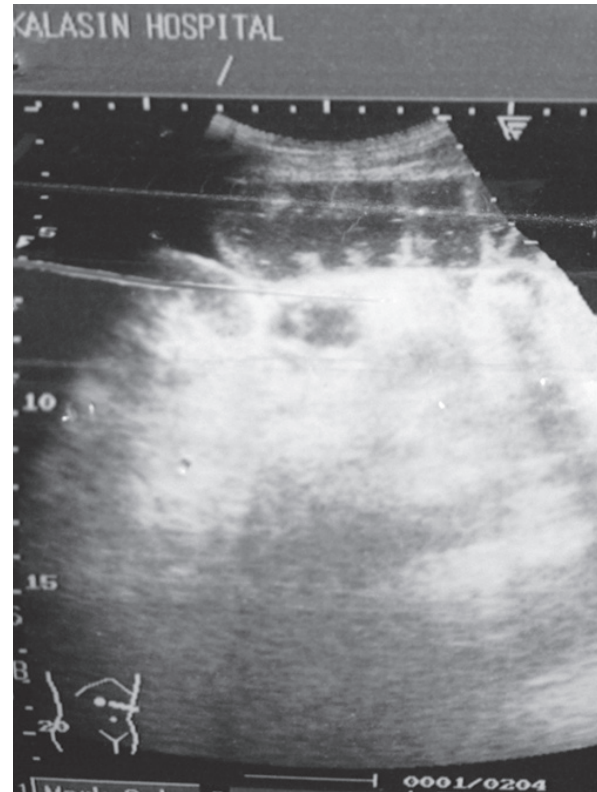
Ultrasonography shows small bowel dilatation with fluid fill dilated small bowel (arrow).
